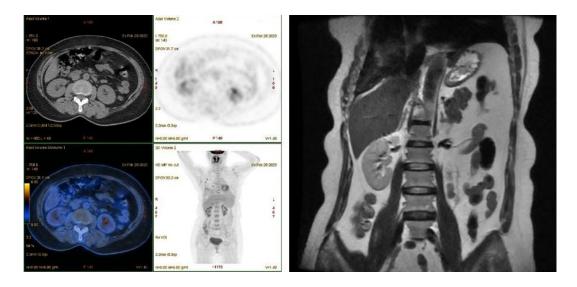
Positron emission tomography-computed tomography whole-body fusion image showing nodular foci in the medial limb of the right adrenal gland; MR scan of the renal region + adrenal glands + angiography enhancement scan suggesting no abnormalities in the adrenal glands bilaterally.
